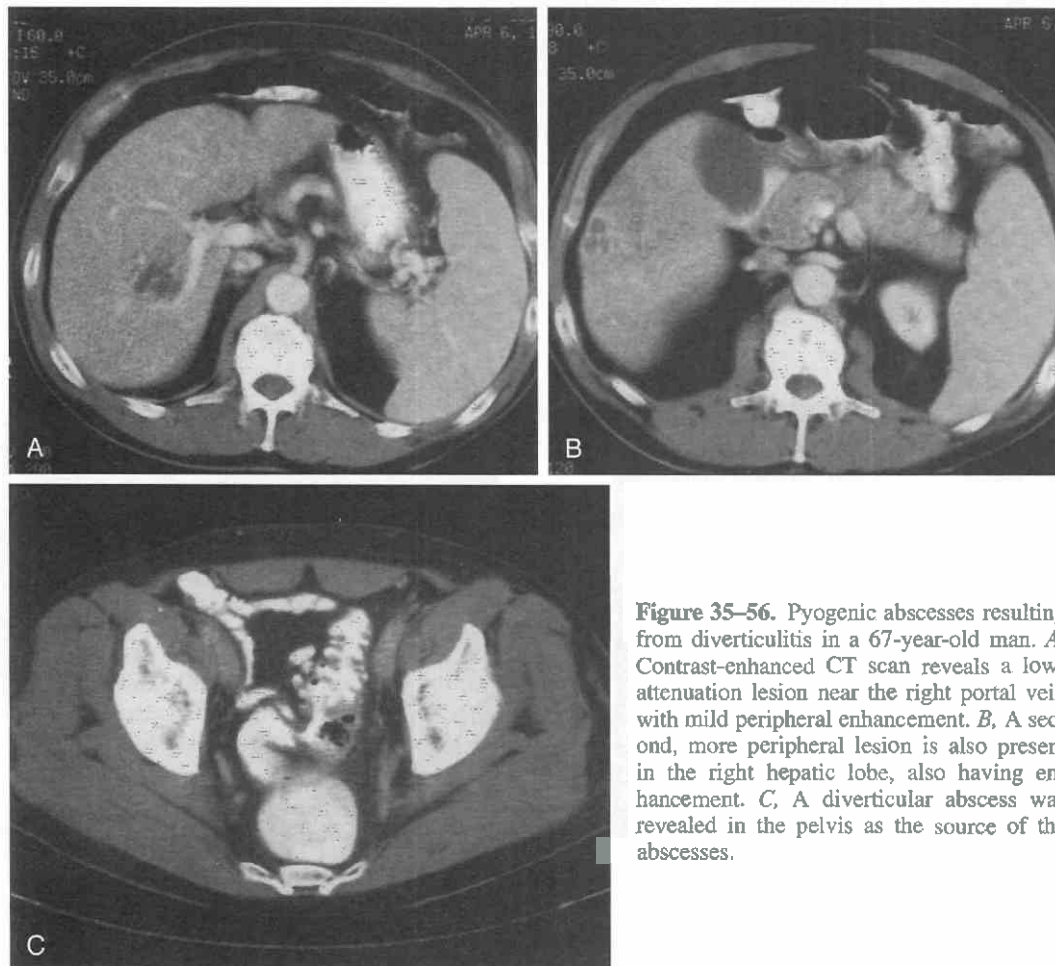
Pyogenic abscesses resulting from diverticulitis in a 67-year-old man. *A*, Contrast-enhanced CT scan reveals a low-attenuation lesion near the right portal vein with mild peripheral enhancement. *B*, A second, more peripheral lesion is also present in the right hepatic lobe, also having enhancement. *C*, A diverticular abscess was revealed in the pelvis as the source of the abscesses.
